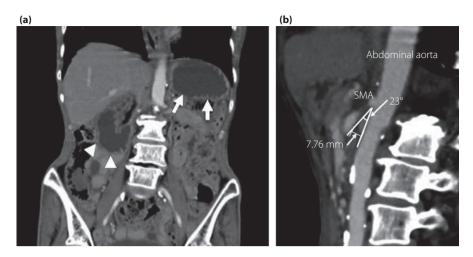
Finding on abdominal contrast computed tomography. (a) This patient's stomach (white arrow) and upper duodenum (white arrowhead) were filled with residue. (b) The horizontal portion of the duodenum was compressed between the superior mesenteric artery (SMA) and abdominal aorta (the aortomesenteric angle: 23° (diagnostic criteria: <25°) and the distance: 7.76 mm [diagnostic criteria: <8 mm]).
